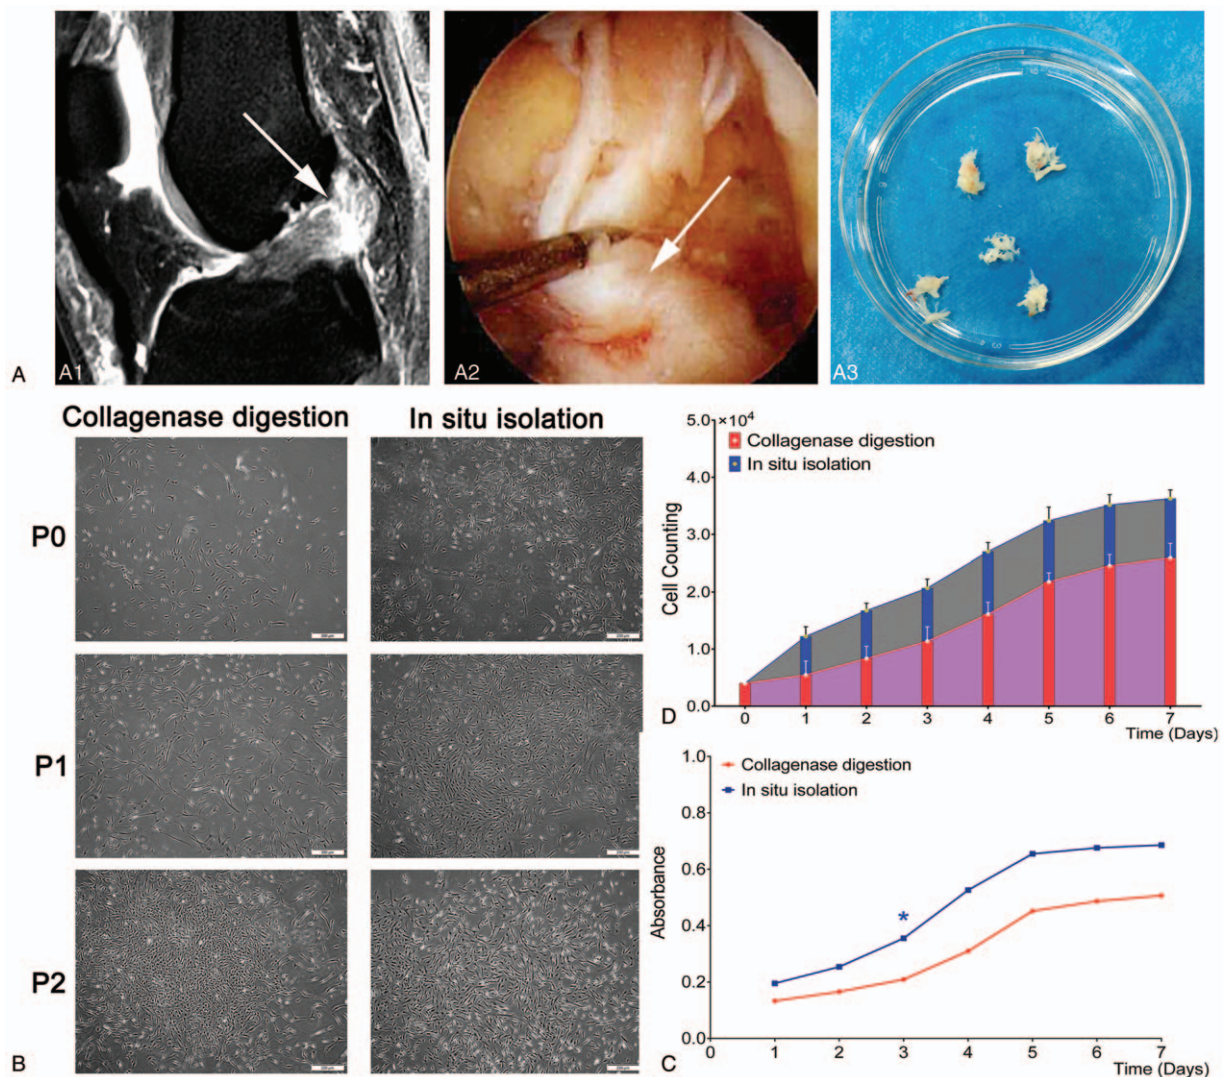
Morphology of isolated hACLFs and proliferative curves and cell counts of cells isolated using two methods. Magnetic resonance imaging (A1). Arthroscopic surgery showed emblematical ACL rupture (A2). ACL tissue was obtained during surgery (A3). Morphology of cultured hACLFs obtained by collagenase digestion or in situ culture of tissue pieces from P0 to P2 (B). (Magnification ×40, bars in Fig. 1B, 200 μm). Cell count (C) and proliferation curve (D) of primary hACLf cultures obtained from collagenase digestion or in situ culture of tissue pieces. Cell count and proliferative curves using the CCK-8 method showed that the proliferation and counts of hACLFs isolated through the in situ culture of tissue pieces were significantly higher than those of hACLFs obtained with the collagenase digestion method (P* < .05).
